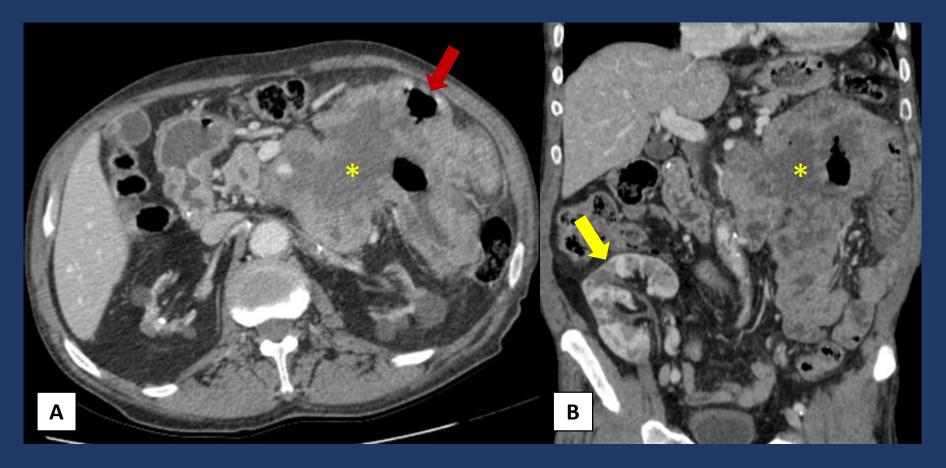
Axial (A) and coronal (B) CT demonstrates a extensive and irregular thickening of a jejunal loop with aneurysmal dilatation (asterisk) and ulceration (red arrow), typical of a small bowel lymphoma. This represent a <u>post-transplant lymphoproliferative disorder</u> after a kidney transplant (yellow arrow) (note the atrophic native kidneys).
